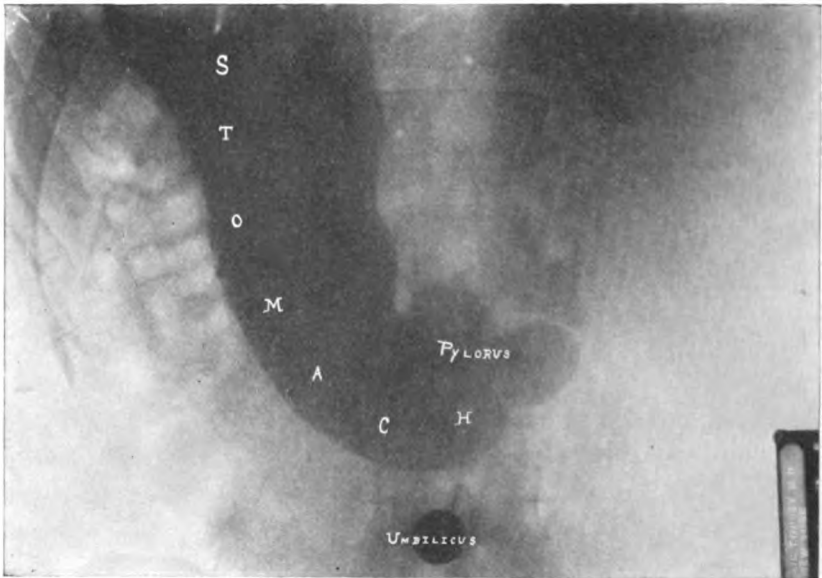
Radiograph showing normal position of the stomach; same case as Fig. 671.
